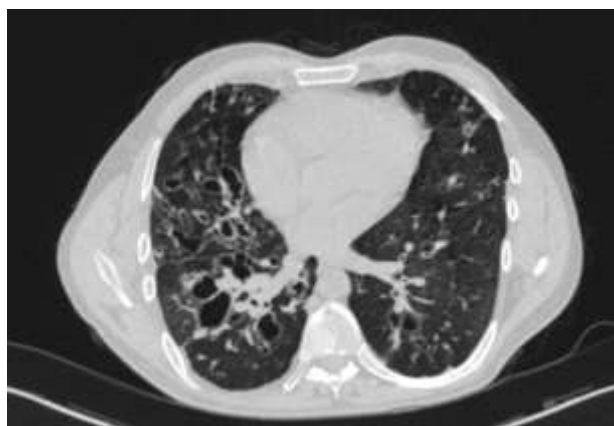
HRCT for 66 years old age male with COPD of mixed phenotype showing widespread bronchiectasis, peribronchial thickening, and small areas of centrilobular emphysema, he had AWD type of COPD, GOLD II score, and CT score of 20.
